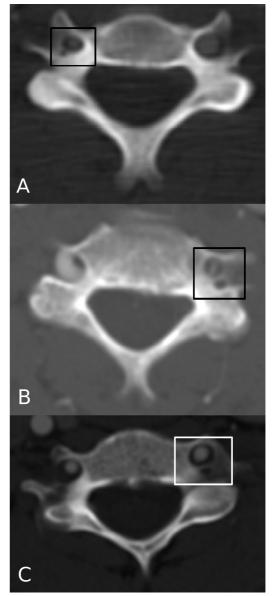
CT scan images of cervical vertebrae with DTF. (A) C4 vertebra with a right DTF. (B) C5 vertebra with a left DTF. (C) C6 vertebra with a left DTF.
